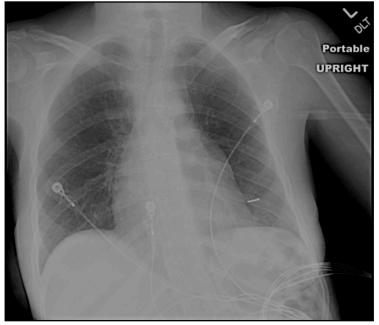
Standard Antero-Posterior Chest Xray demonstrates right atrial enlargement, and cardiomegaly.
